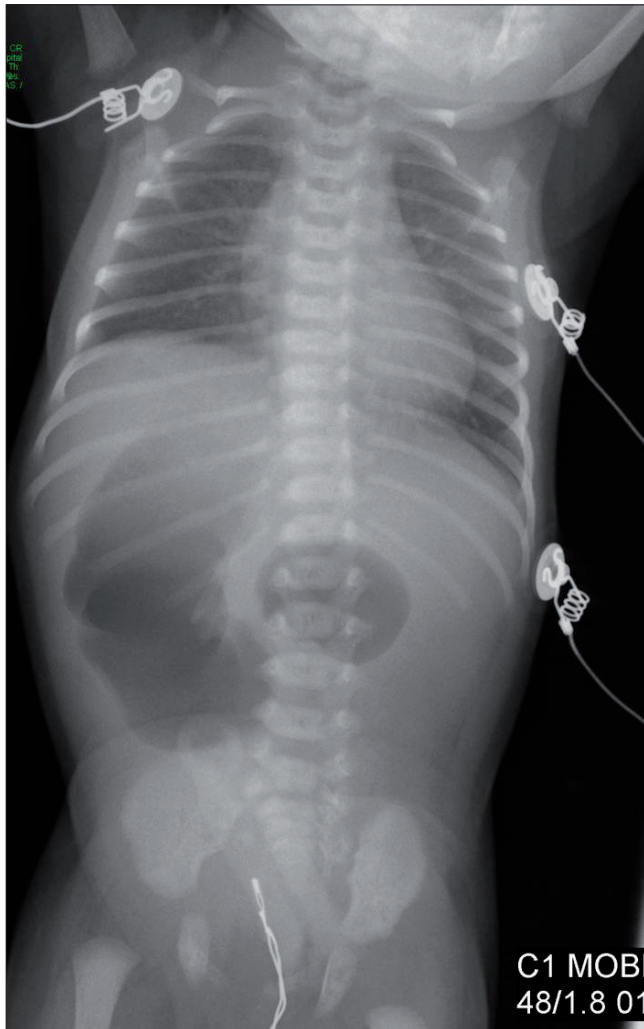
Abdominal radiograph showing duodenal atresia with mirror image configuration of normal anatomy.
